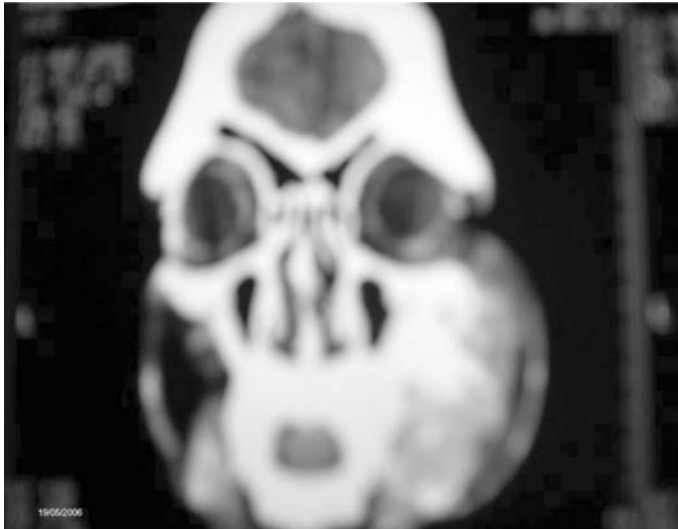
3. CT scan showing typical sunray appearance of osteosarcoma
